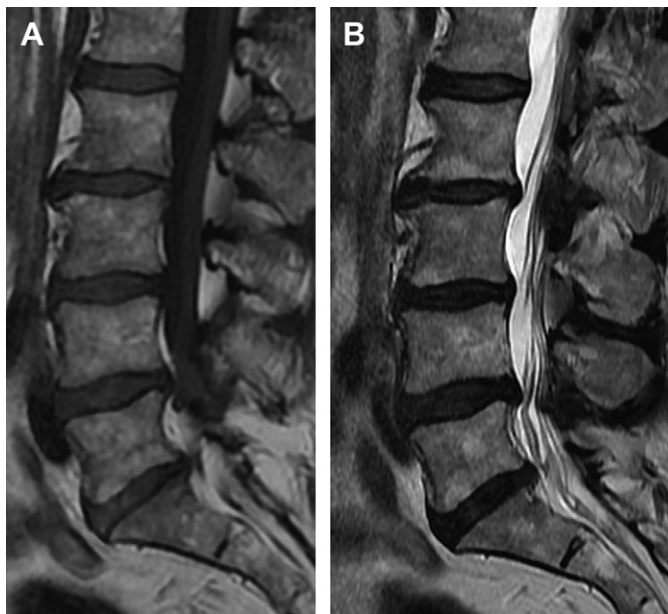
A 33-year-old woman with chronic LBP for 1 year and left-sided sciatica for 4 months. T2-weighted sagittal MRI images showed disk degeneration from L3 to S1. An L4/5 discectomy was performed, and on last follow-up the patient was asymptomatic.
